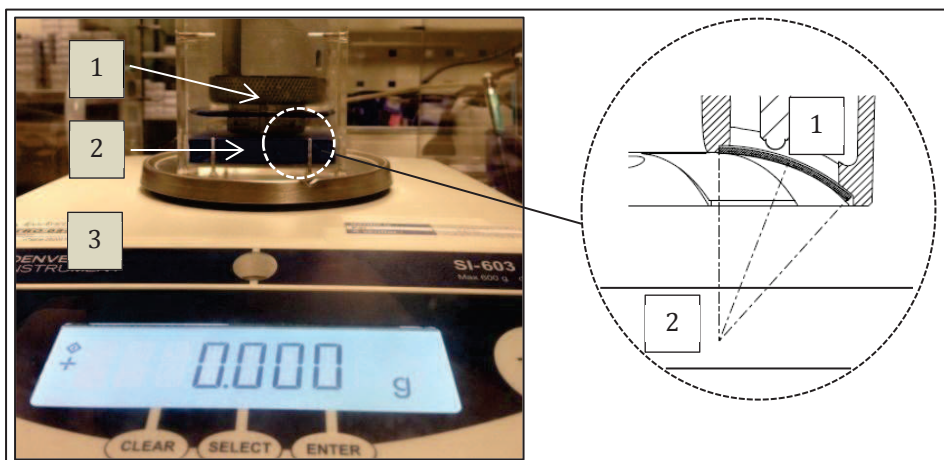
Force balance measurement set-up. (1) therapy probe; (2) ultrasonic absorber; (3) balance.
